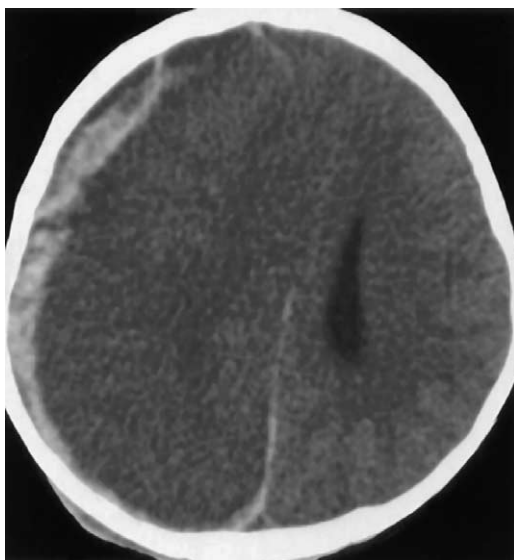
Axial CT image of a 4-year-old girl demonstrating an acute subdural hematoma on the right with mass effect obliterating the right lateral ventricle and midline shift to the left. Note the less dense crescentic portion of the hematoma more superficially along the frontal regions with the higher density clotted subdural hematoma.
